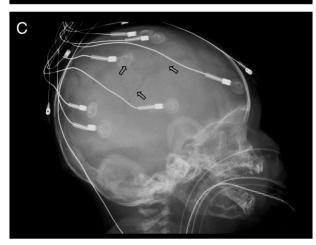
Reformatted three-dimensional CT images of the skull reveal a stellate pattern of linear lucencies joined centrally in the right parietal bone (A) and three orthogonally oriented lucencies joined centrally in the left parietal bone (B). Lateral radiograph of the skull from the skeletal survey (C) also shows the branching lucencies (arrows), which correspond to the CT findings and ultimate diagnosis of anomalous intraparietal sutures. Figs. 1 and 2 reprinted with kind permission from Springer Science + Business Media: Pediatric Radiology, SPR 2015, Volume 45, 2015, S159, Eklund M, Taylor M, Riemer E, Hill J, and Stalcup S.
